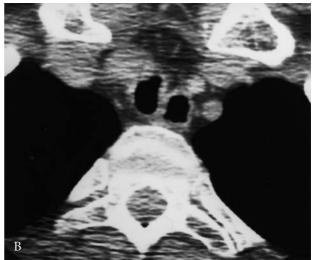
Tracheal lymphoma. A, Anteroposterior tracheal tomogram reveals a smooth stenosis of the proximal trachea with an hourglass configuration. B, Computed tomography scan demonstrates thickening of the tracheal wall.
